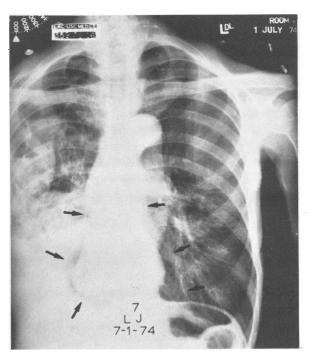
Roentgenogram of chest on 28th hospital day showing pneumopericardium (arrows). Note also small pneumothorax at right upper lung field.
